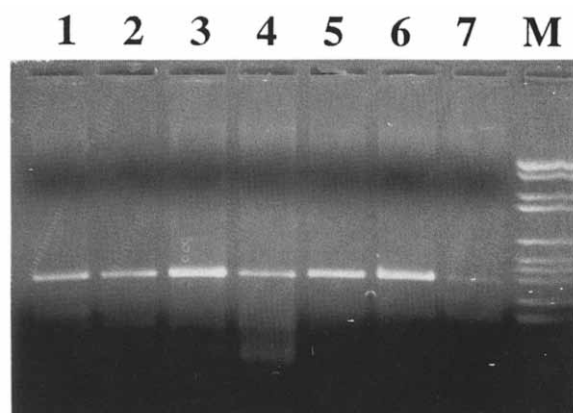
Agarose gel analysis of PCR products. Total RNA extracted from the tumor was reverse transcribed and amplified with specific CT mRNA primers. One-fifth of the reaction was submitted to gel electrophoresis. (Lanes 1-6) Tumoral tissues; (lane 7) control thyroid. Molecular weight markers (M) consisting of the 2.17 kb, 1.76 kb, 1.23 kb, 1.03 kb, 0.65 kb, 0.51 kb, 0.45 kb, 0.39 kb, 0.29 kb, 0.22 kb and 0.15 kb *Bgl*I and *Hinf*I restriction fragments of pBR 328. The 1.2% agarose gel contained 0.5 µg/ml ethidium bromide.
